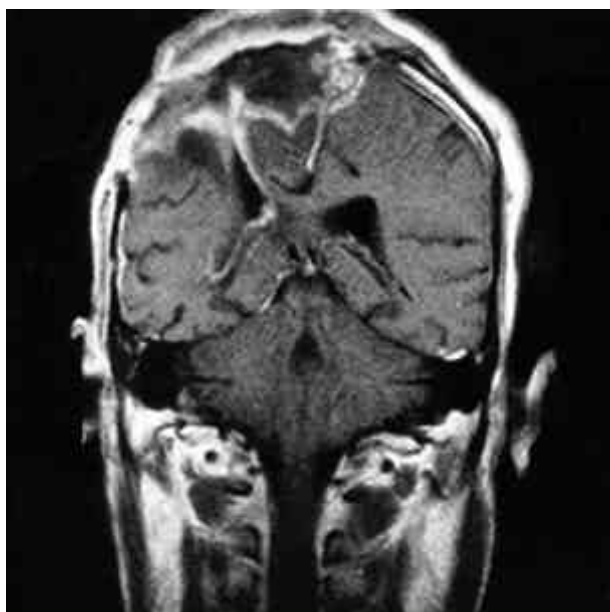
Gd-DTPA enhanced T1W1 MRI, post-IORT followed by third surgery, reveals a marked reduction of mass in volume as compared with pre-IORT and surgery state. Small portion of residual peripheral enhancing lesion and gliotic reaction is noted.
